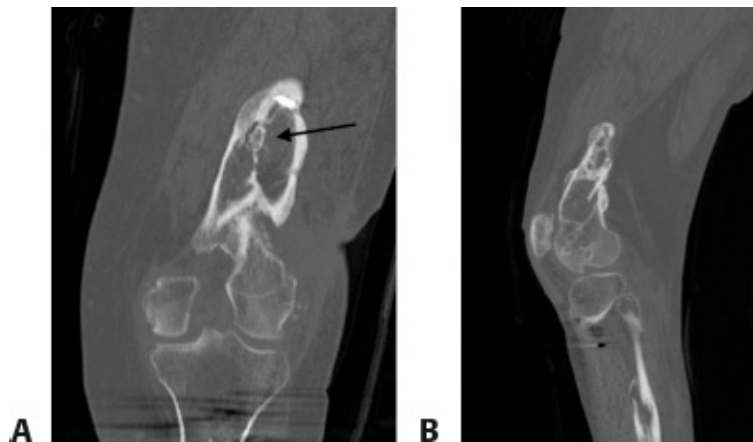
• A. Coronal and sagittal (B) CT scan of the distal femur with chronic osteomyelitis demonstrating sclerotic rim of the bone (involucrum) surrounding a spicule of the bone (sequestrum, *arrow*).
